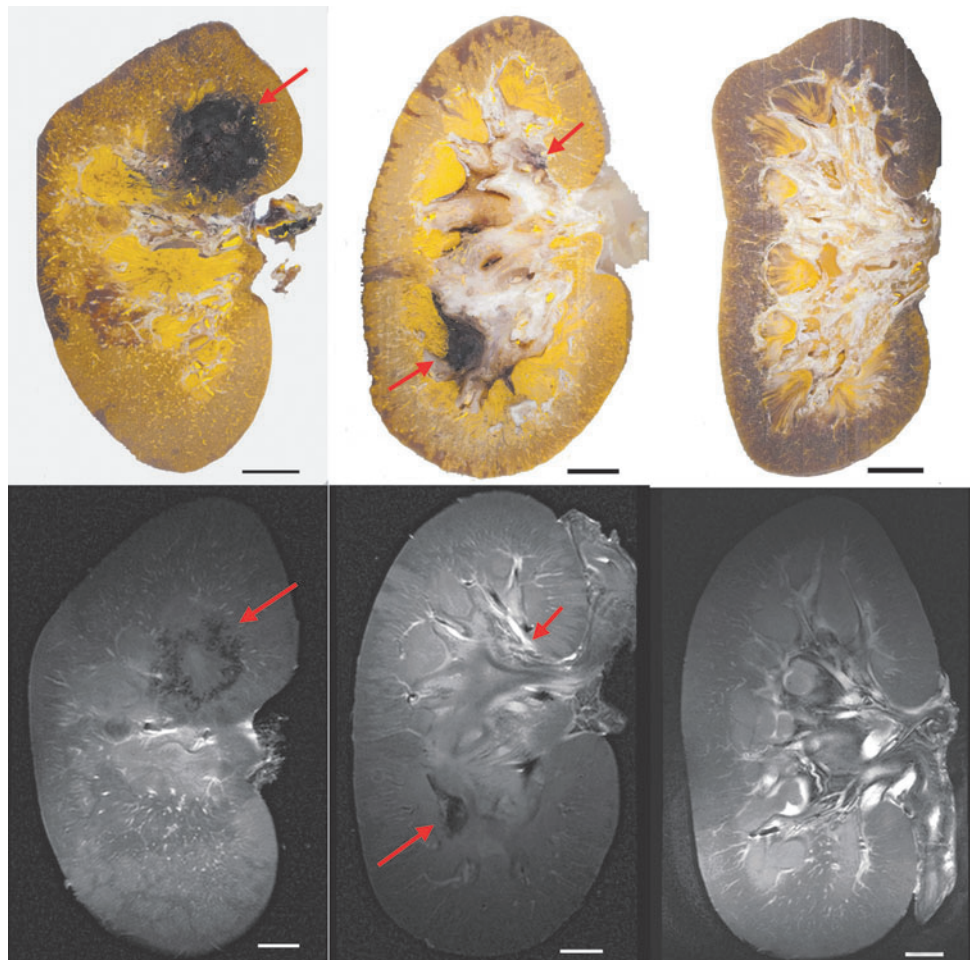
Histomorphometric image slices (top row) and corresponding T2-weighted images (bottom row) with injury sites denoted by red arrows. Following the identification of treatment sites described in Fig. 3, left panels show injury site 2-M n; middle panels show injury sites 3-U and 3-L; and right panels show images from kidney 8, in which no hemorrhagic injury occurred. Scale bars represent 1 cm.
